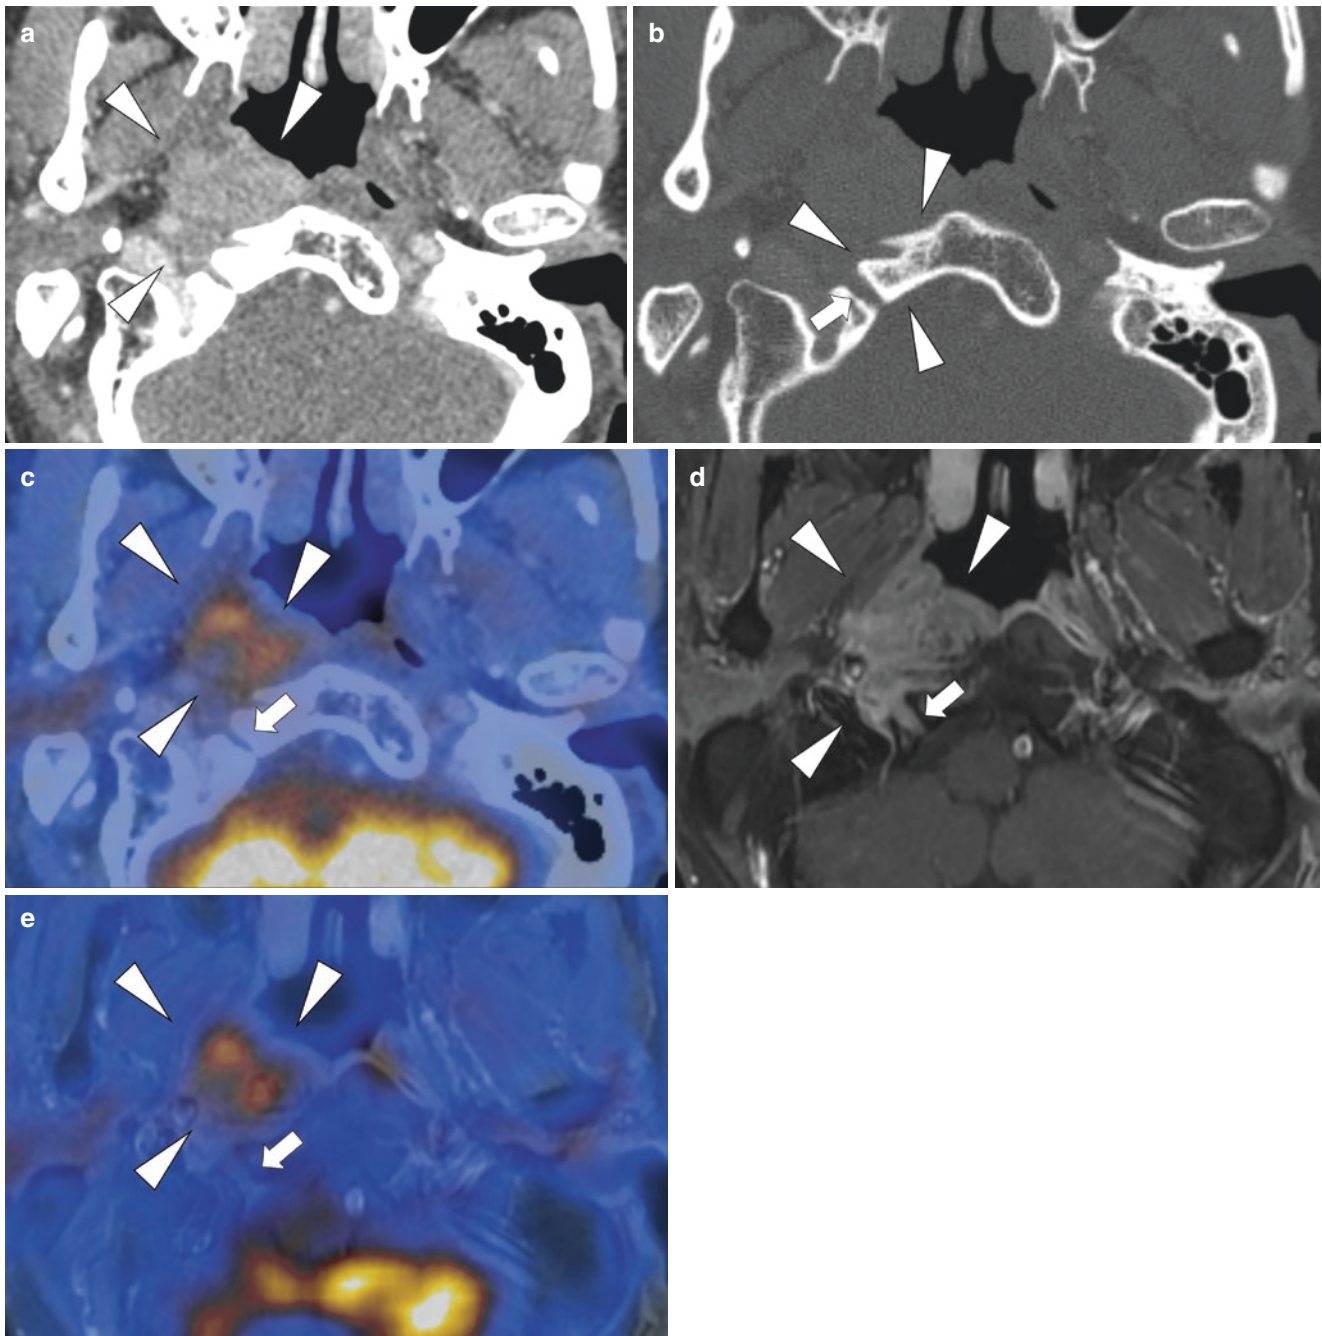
A 54-year-old man after three cycles of cisplatin-based chemotherapy for a poorly differentiated nasopharyngeal carcinoma. Contrast-enhanced CT images in soft tissue window (a) and bone window (b) showed a mass in the nasopharynx on the right side (a, *arrowheads*) with parapharyngeal infiltration. Sclerosis was seen in the clivus adjacent to the mass (b, *arrowheads*). The hypoglossal canal was not widened (b, *arrow*). Fused PET/CT image (c) demonstrated moderate FDG uptake of the mass (*arrowheads*), but no increased FDG uptake within the hypoglossal canal (*arrow*). Contrast-enhanced T1-weighted
